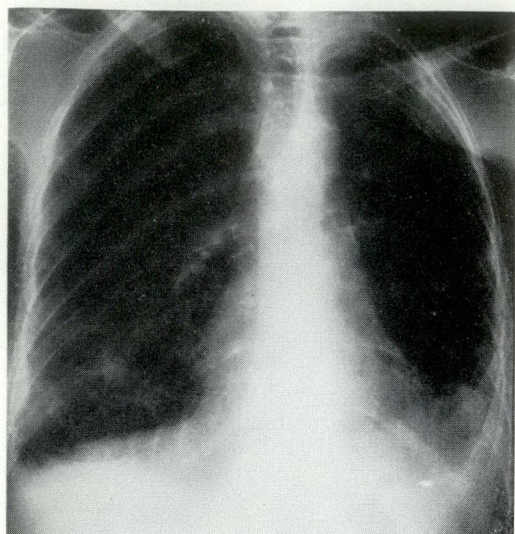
Posteroanterior chest radiograph, June 4, 1964. There is no recurrence of fluid in the pericardial space or in either pleural space nine months from the time of right thoracotomy and talc poudrage.
